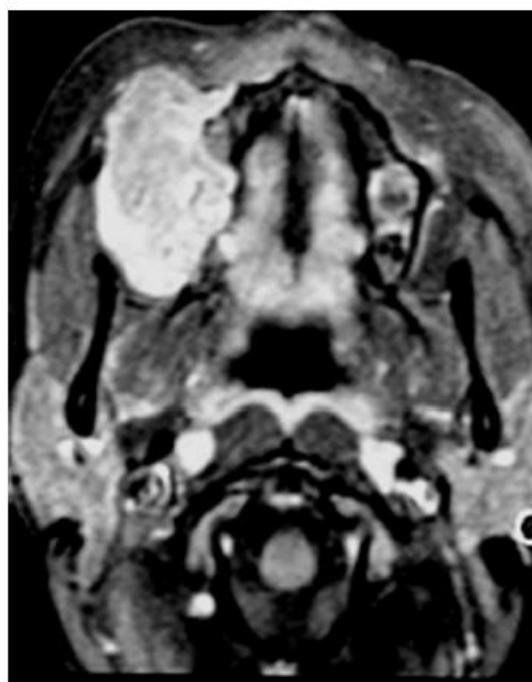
Axial T1 post(gadolinium)-contrast MRI at the level of the alveolus. Peripheral areas markedly enhanced, whereas the center and anterior area of the mass enhanced weakly. Differences in the pattern of contrast uptake reflect different composition of the mass, which is mostly collagenous at the periphery and myxomatous toward the center and anterior area at this level.
